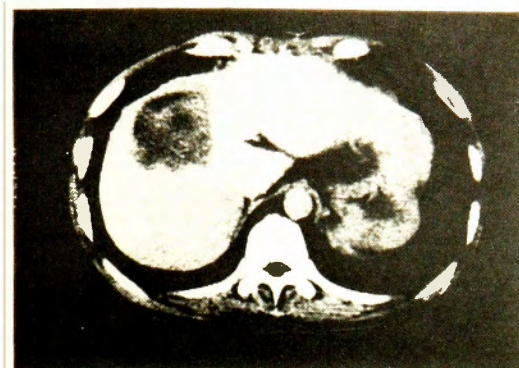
Computed tomogram obtained 1 month after operation in case 2. The low density area corresponds to the site where the tumor existed until excised.
